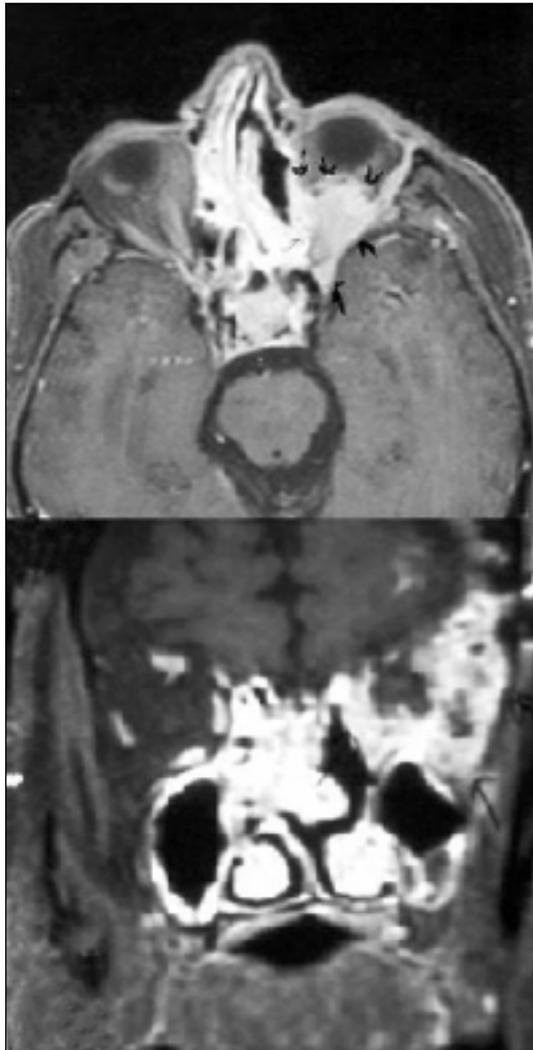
Left orbital magnetic resonance imaging.
